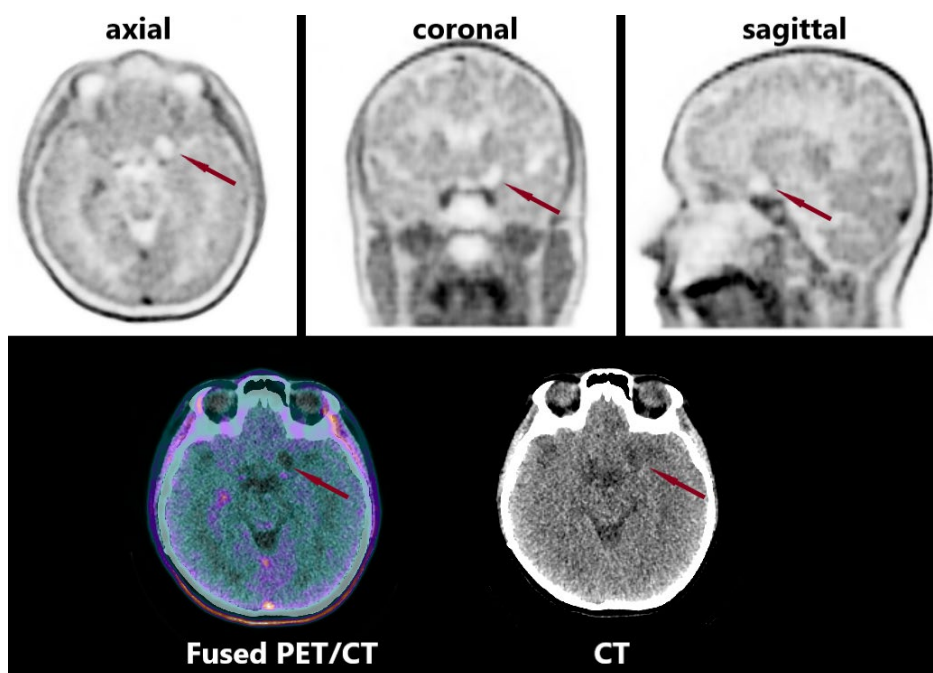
40-year-old female patient with oligoastrocytoma WHO grade 4 after surgical treatment for twelve years and twelve cycles of adjuvant chemotherapy for five years. Diffuse, slightly physiological accumulation of ^{18}F -FET in gray matter, glandular structures, and venous vessels. A lack of tracer's uptake frontobasal left in PET corresponds to a hypodense postoperative liquor-filled area on CT corresponding to the area of surgery (red arrows).
